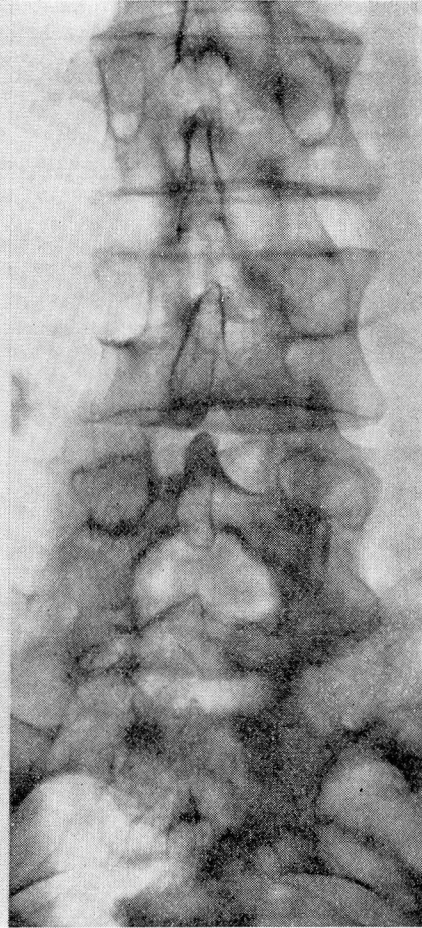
Roentgenogram made after drainage of subarachnoid space. The efficacy of the drainage is obvious.
